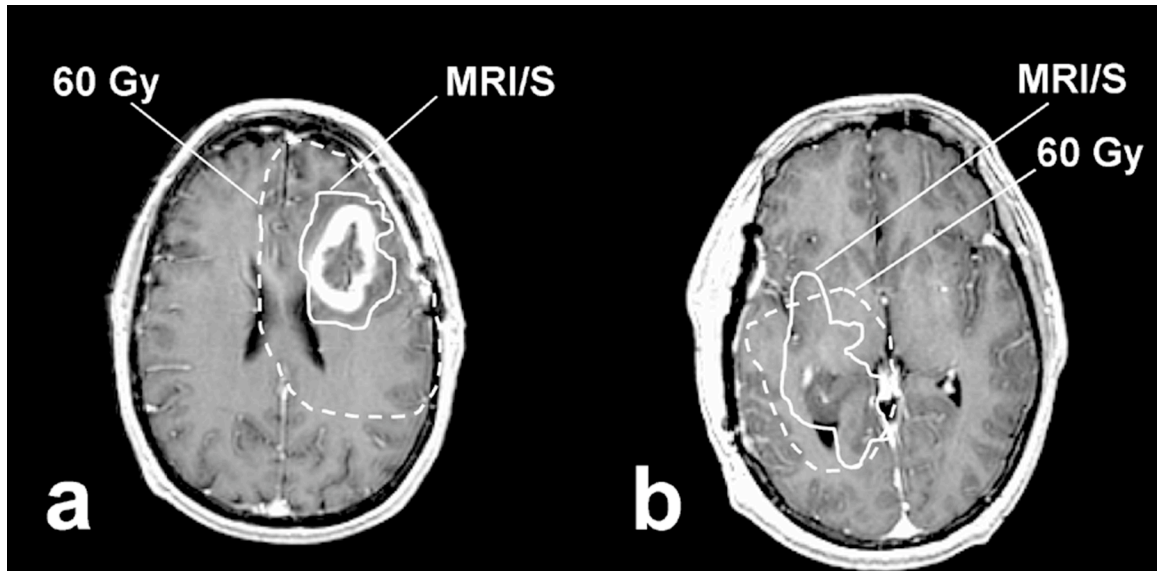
Examples comparing the volume of a combined anatomic and metabolic region of interest (MRI/S; solid line) and the actually delivered 60 Gy (dashed line). (a) Typical volume of 60 Gy compared with that of MRI/S, which had a large portion of normal-appearing brain tissue that received 60 Gy; (b) case in which MRI/S extended beyond 60 Gy.
